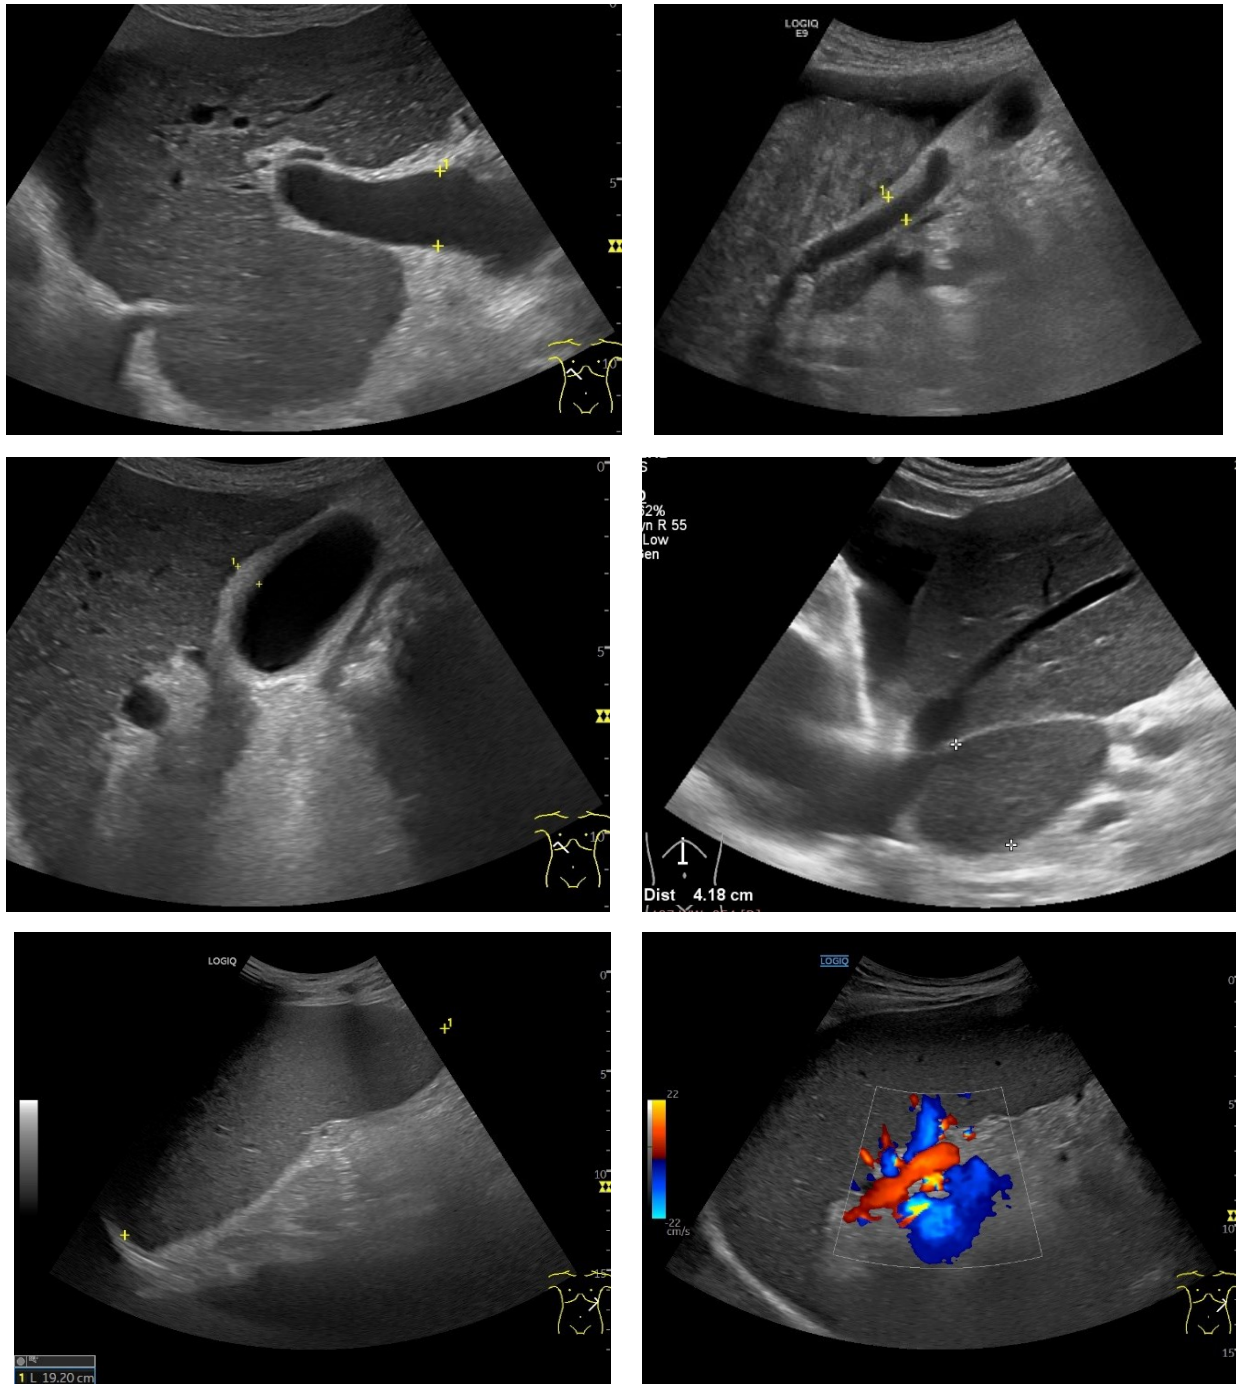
A-F. Ultrasound Findings Indicative of Portal Hypertension and Liver Cirrhosis
